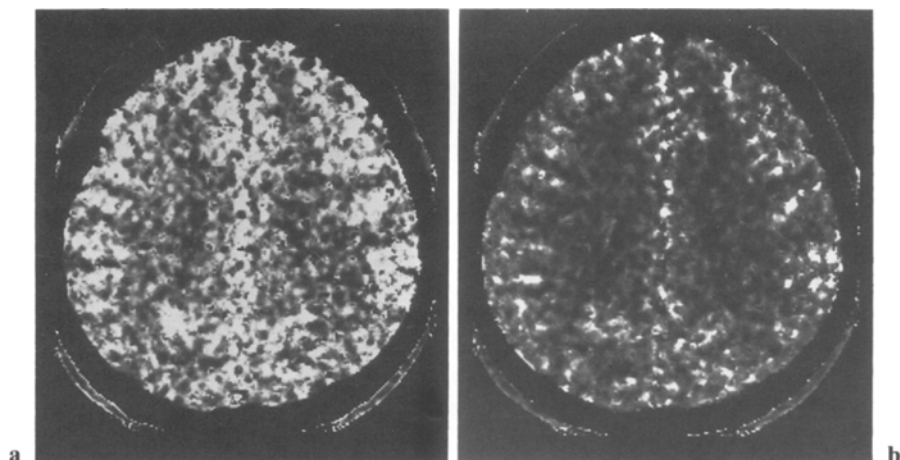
Xenon computed tomography/cerebral blood flow images in a patient anesthetized with fentanyl and diazepam a during normoventilation ($P_{aCO_2} = 40.8$ mmHg), and b during hyperventilation ($P_{aCO_2} = 33.4$ mmHg)
